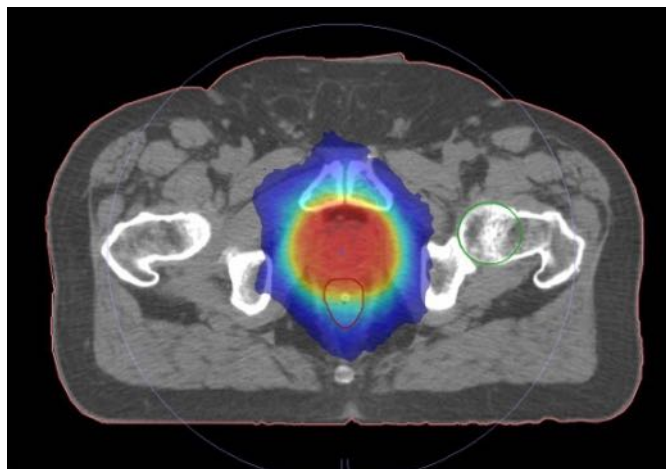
Image-guided radiotherapy for prostate cancer with cone beam CT: dosimetric effects of imaging frequency and PTV margin
